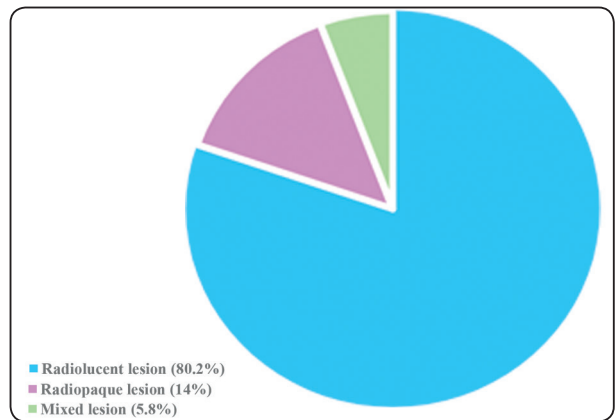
Shows the percentage of the radiographic lesions.
